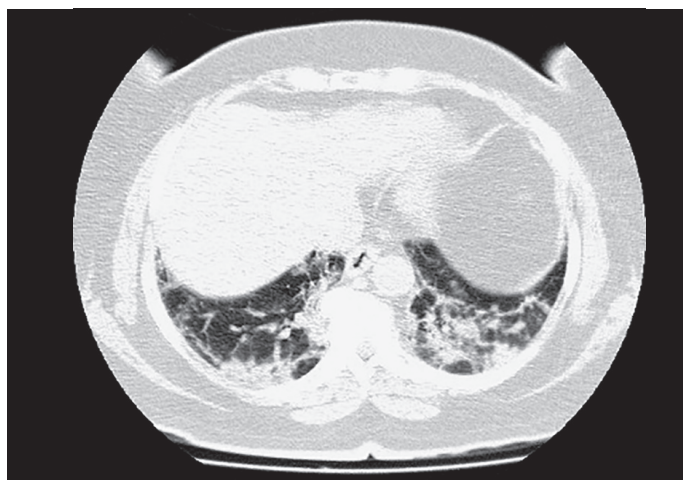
Follow-up chest-CT on day 7.
